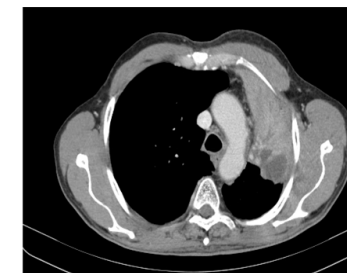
Consolidation in CT scan (Pre treatment)
